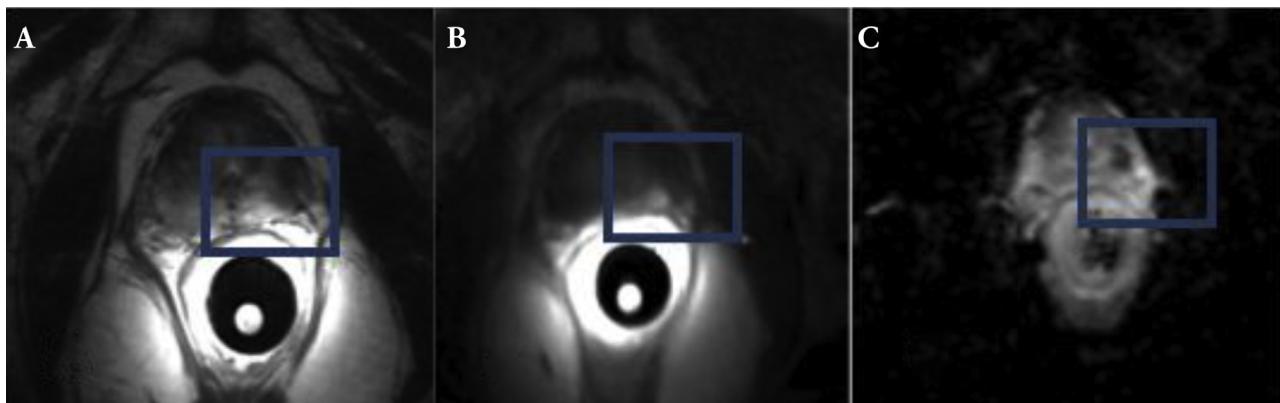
Multiparametric magnetic resonance imaging (mpMRI) sequences (from left to right). (A) T2-weighted (B) dynamic contrast-enhanced, and (C) apparent diffusion coefficient images taken during the interventional procedure depicting areas of high tumour density in the blue box. (Color version of figure is available online.)
